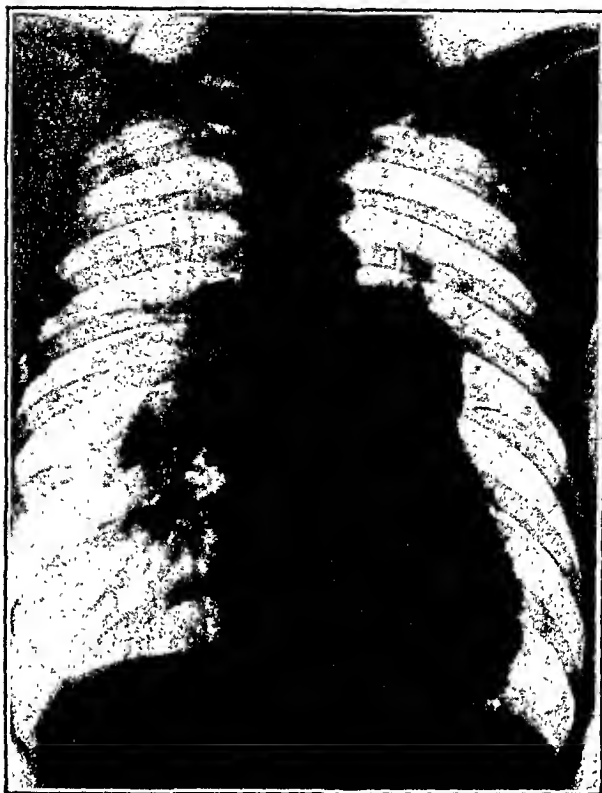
J. T., a seven-year-old schoolboy with rheumatic cardiovalvular disease for two years. Patient in persistent cardiac failure. The roentgenogram shows generalized cardiac enlargement and excessive dilatation of the left main branch of the pulmonary artery. The aorta is not seen in this view, indicating rotation of the heart. These findings were confirmed fluoroscopically and at autopsy.
